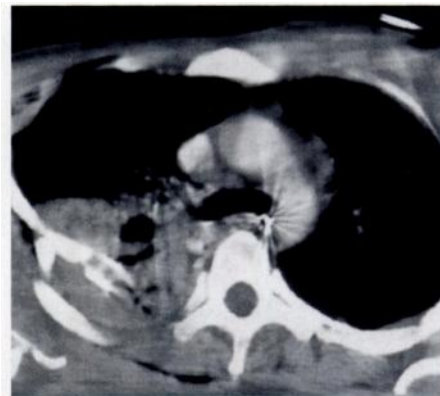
Findings subtly positive for mediastinal hematoma. Contrast-enhanced CT scan of chest reveals a small fluidlike density adjacent to anterior wall of aortic arch in a 50-year-old man with a closed head injury from a motorcycle accident. Note fractures in right scapula and right posterior part of rib cage plus fluid (blood) in posterior part of right hemithorax. Findings on thoracic aortogram were considered to be normal, and a subsequent abdominal aortogram showed a splenic injury.
